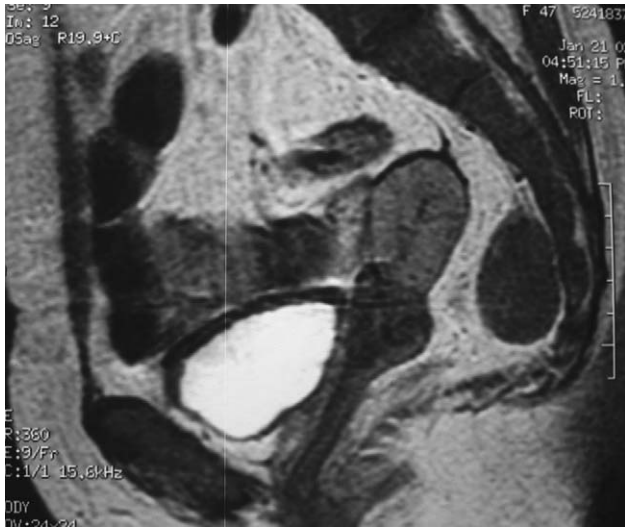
Magnetic resonance imaging of the abdomen and pelvis: sagittal view. A clearly demarcated presacral mass is shown.
